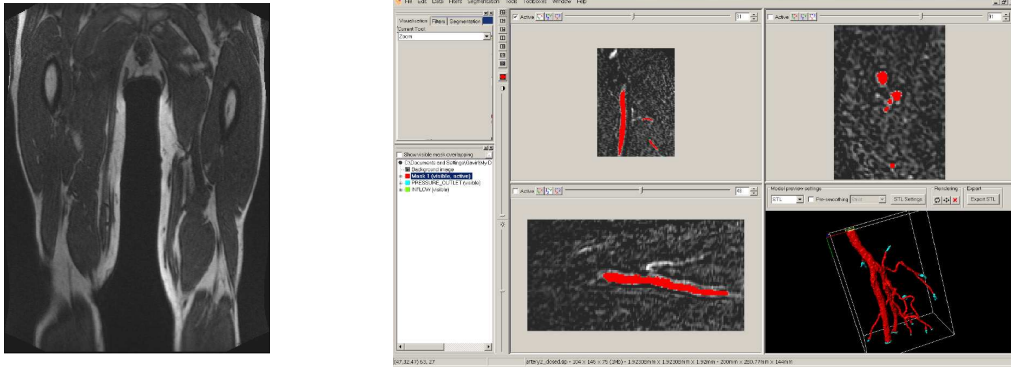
Left:Raw MRI slice of patient. Right: ScanIP segmentation to define artery network region.
